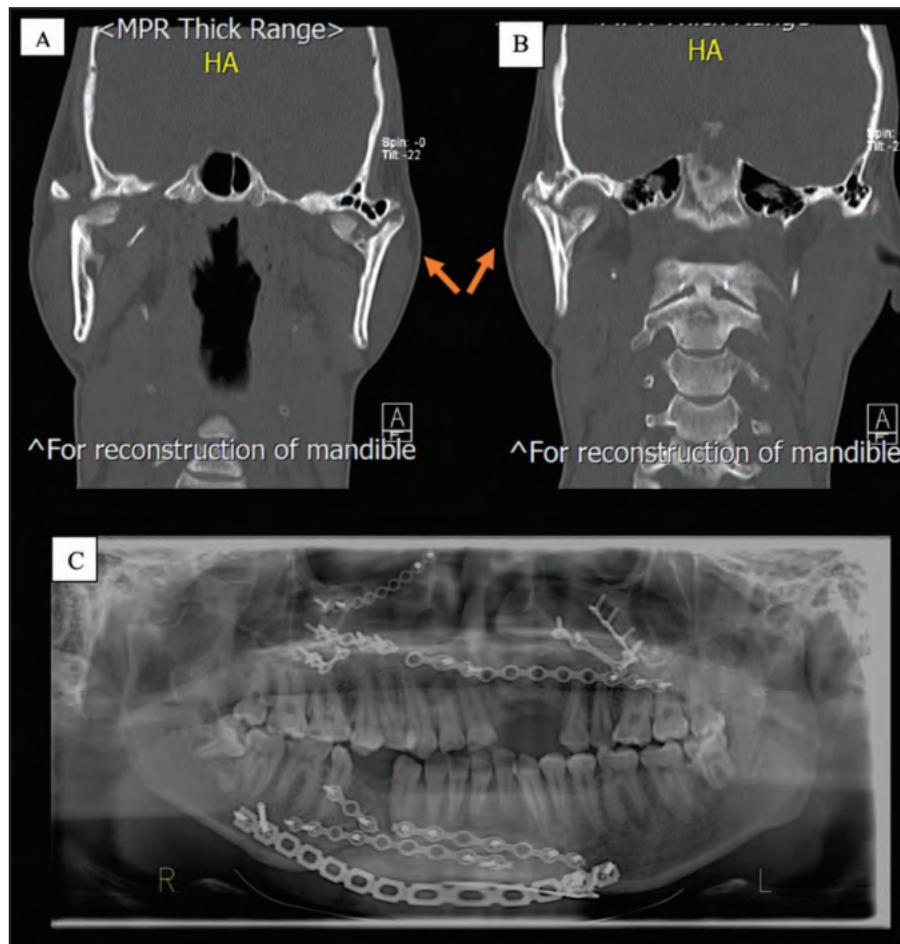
A & B: Dislocation of the medial segment of fracture, with a widening of the intercondylar distance and the distal aspect of bilateral condyle, appears to have moved superolateral leading to widening of the midface clinically (arrow) (C): Orthopantomogram showing bilateral ill-defined condyle, loss of bilateral synovial cavity, and reconstruction plate over the lower border of mandible.
